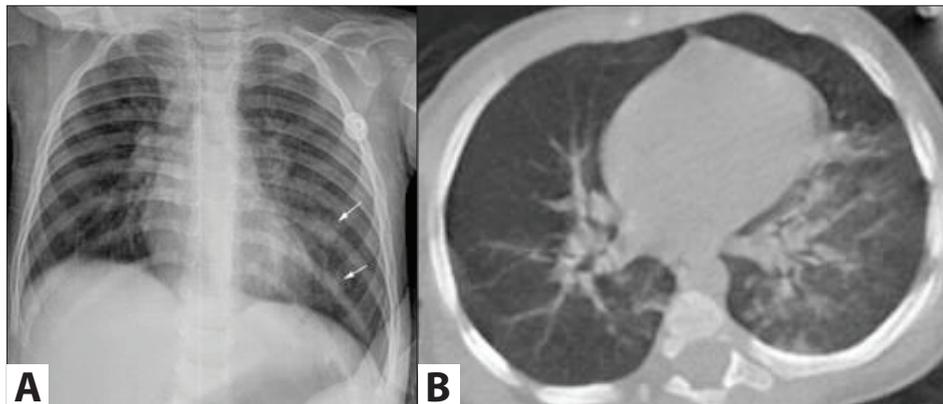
Two-year-old female with Coronavirus disease, two days after symptom onset. (A) Chest X-ray (CXR) shows bilateral perihilar peribronchial wall thickening with ground glass opacities in the left lung (arrows). (B) Axial and (C) coronal CT images obtained one day after the CXR displays bilateral bronchial wall thickening with ground-glass opacities and consolidation, predominantly in the left lower lobe.
